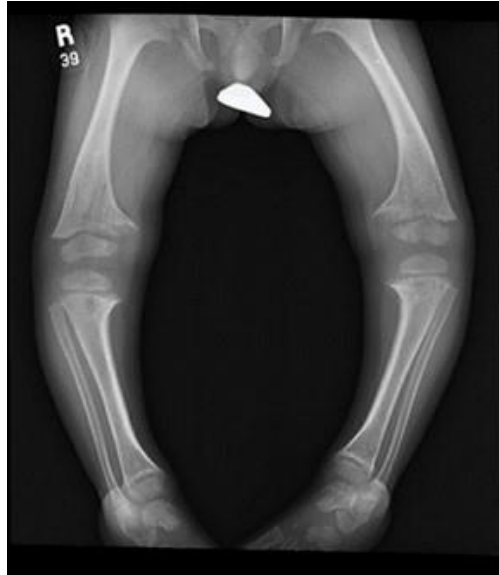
Radiograph of the lower limbs showing bilateral genu varum in patient #7
